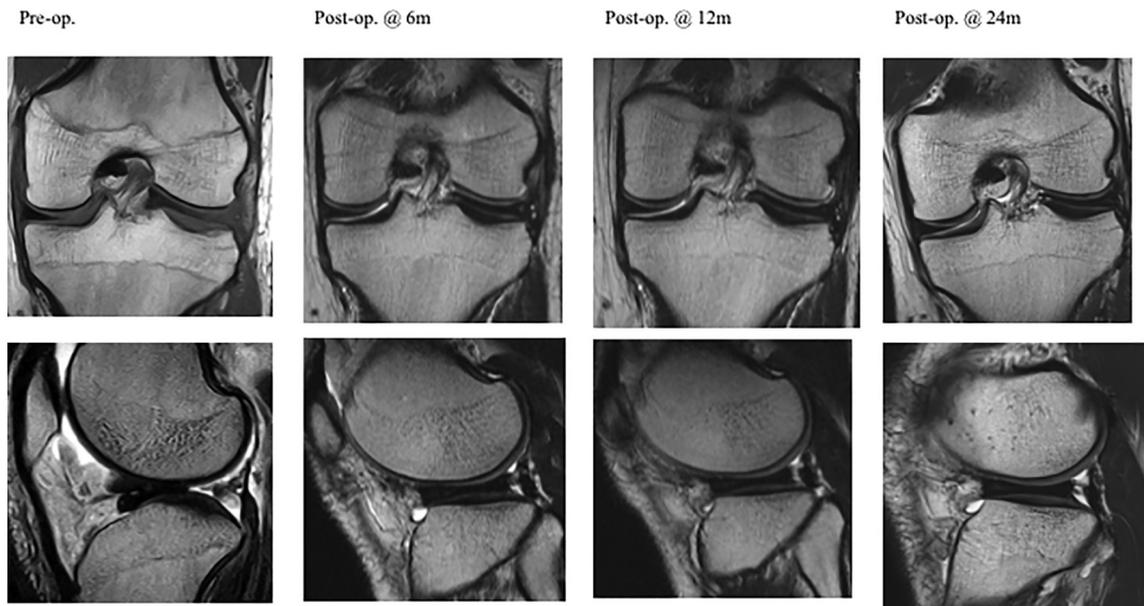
The MRI findings for Case 3 pre-operatively and postoperatively at six, 12, and 24 months. In MRI at pre-operative phase, it was confirmed that posterior portion of DLM overturned onto the anteromedial portion and caused locking. (Antero-central shift type according to Ahn et al.) In MRI at postoperative phase, DLM was reduced to the normal position and observed to have a discoid shape morphology. The discoid shape was preserved and neither deformation nor extrusion was found postoperatively within 2 years. Pre-op. = preoperative; Postop. = Postoperative; m = month.
